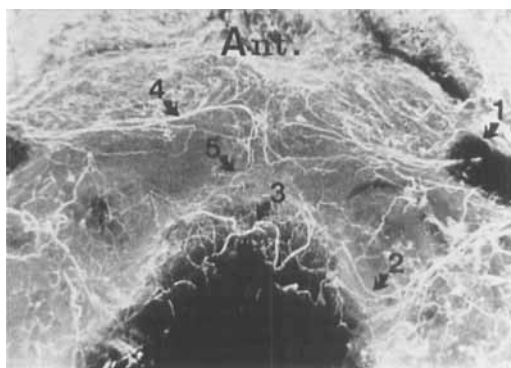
Horizontal section through the uppermost part of the cervical spine. Radiograph of Spalteholtz preparation. (cf. Figure 4 c, no. 1; slice thickness 12 mm). Seen from above and posteriorly.
